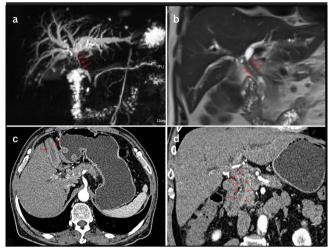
a-d. Abdominal MRI+MRCP and enhanced abdominal CT: a) MRCP reveals obvious stenosis of the common hepatic duct and common bile duct in the upper pancreatic segment (red arrow), with a tail-like change; the main pancreatic duct of the pancreatic tail shows a bead-like change. b) Coronal T2 WI shows diffuse annular thickening of the common hepatic duct and a common bile duct with stenosis (red arrow), eccentric nodules in the lower segment of the common bile duct, and a suspicious tumor in the lower segment. c) Uniform thickening of the gallbladder wall (red arrow), enlarged lymph nodes (white arrow) in the posterior common bile duct, obvious annular thickening of the common bile duct, a full pancreas, and an anterior fibrosis sheath are shown. d) CT with coronal reconstruction shows further extrahepatic bile duct thickening (red arrow), and the lumen is almost occluded.
